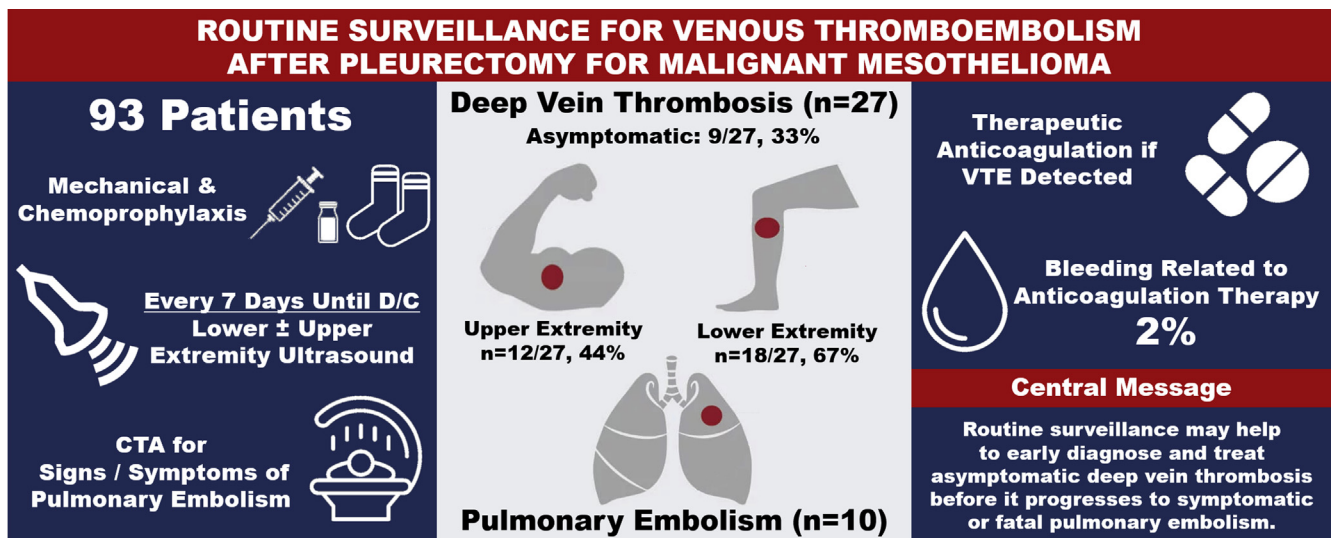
We implemented an aggressive surveillance protocol for VTE in 93 patients undergoing pleurectomy for mesothelioma. Patients received mechanical and chemoprophylaxis perioperatively and were followed every 7 days postoperatively, or earlier if symptomatic, with upper- ± lower-extremity ultrasounds. CT-PA was used to investigate patients who developed signs or symptoms suggestive of PE. Twenty-seven patients developed DVT, 9 of whom were asymptomatic; 10 patients developed PE. Therapeutic anticoagulation was initiated in these patients. There was only a 2% incidence of bleeding events related to therapeutic anticoagulation. D/C, Discharge; CTA, computed tomography angiogram; VTE, venous thromboembolism.
